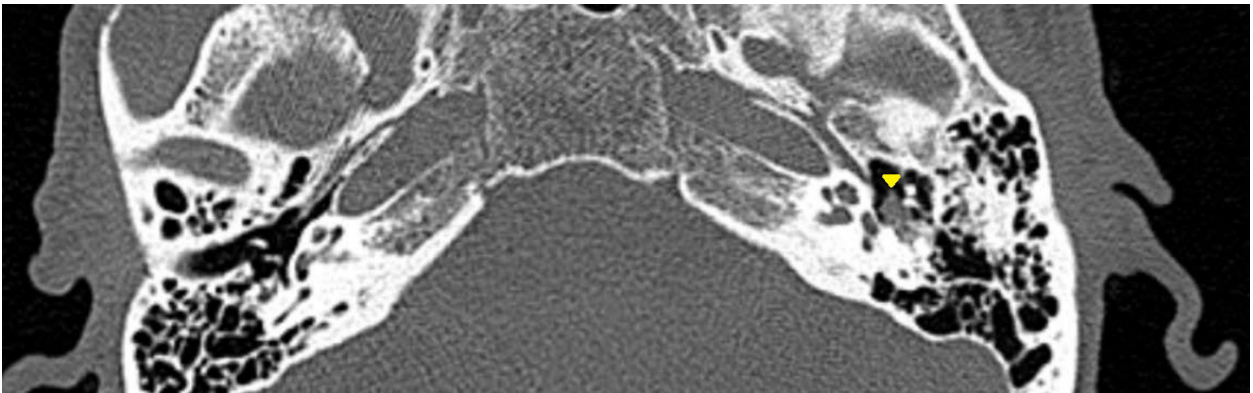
CT of the patient with hemangioma of the tympanic segment. Note the soft tissue attenuated mass centered in the tympanic segment of the facial canal.
